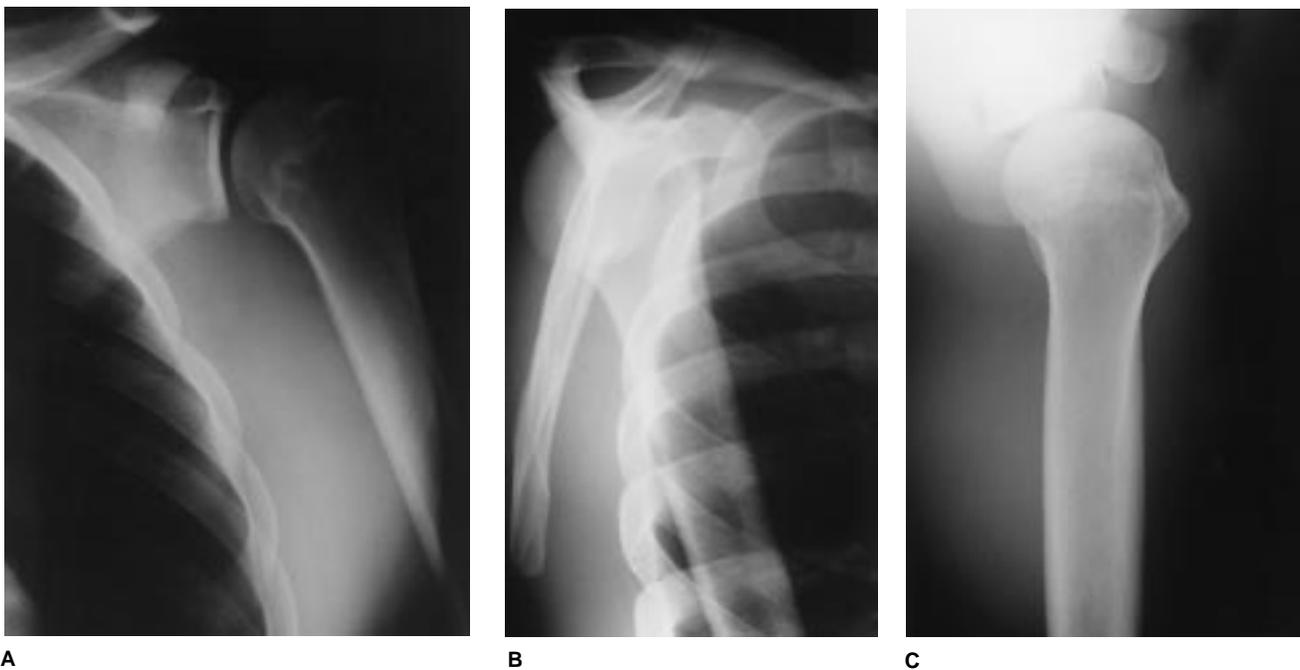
Standard radiographic examination of the shoulder. A, Anteroposterior view. B, Lateral scapular view. C, Lateral axillary view.
